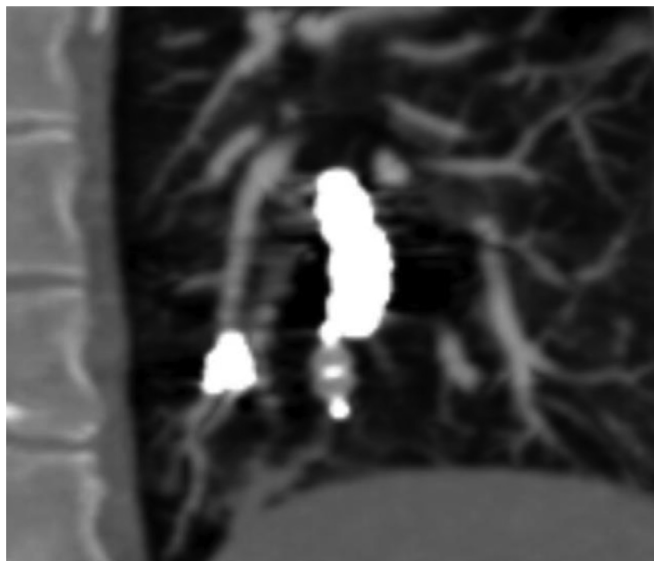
Four-month follow-up CT angiogram demonstrating involution of AVM nidus.
